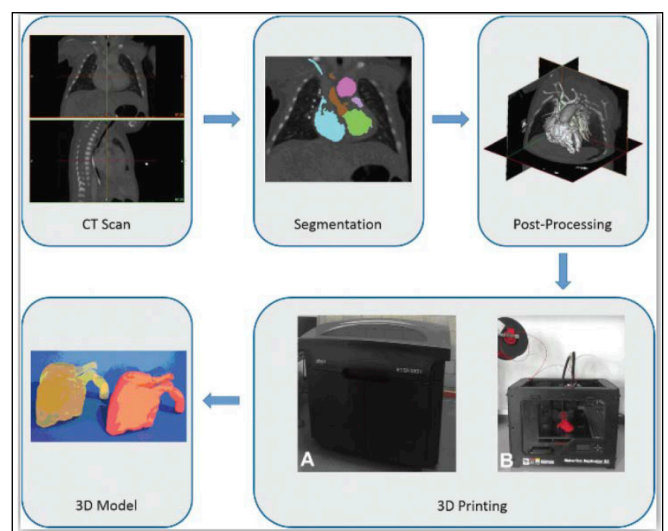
3D printed congenital heart defects model from CT scan data (Pati et. al. 2016)
